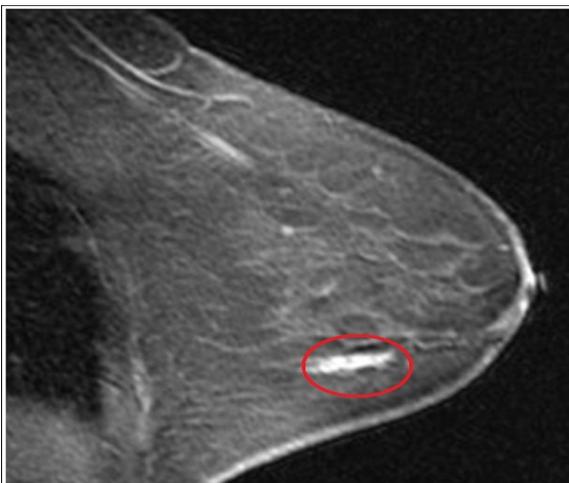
Breast MRI. *Linear/ductal* contrast enhancement pattern of a DCIS lesion.
